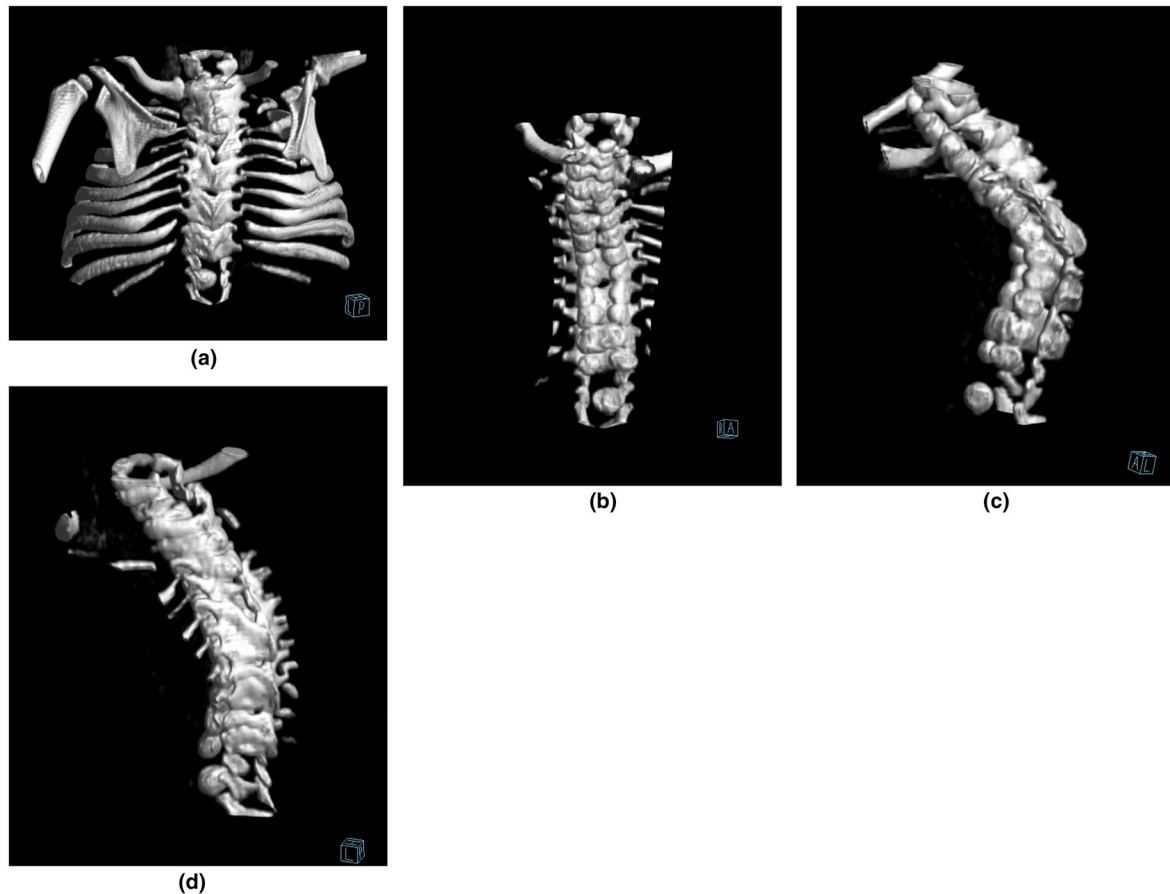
CT-scan 3D-reconstruction of thoracic skeleton at age 11 months, (a) hypoplasia of the first rib, bifurcation of the third rib on both sides with a whole of 11 ribs on either side. (b) Lacking ossification at the ventral side of the vertebral bodies. (c) Lacking ossification of the pedicles. (d) Multisegmental, partial fusion of the vertebrae in the median and lower thoracic spine
